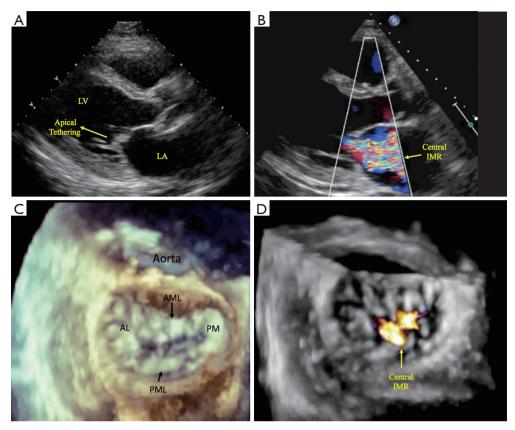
Symmetric pattern of mitral valve tethering on two- and three-dimensional echocardiography. Symmetric mitral valve leaflet tethering in primarily the apical direction results in a central ischemic mitral regurgitant jet (A,B). En face (surgeon's view) of the mitral valve exemplifies a central, crescentic-shaped regurgitant orifice and MR jet (C,D). AL, anterolateral commissure; AML, anterior mitral leaflet; IMR, ischemic mitral regurgitation; LA, left atrium; LV, left ventricle; PM, posteromedial commissure; PML, posterior mitral leaflet.
